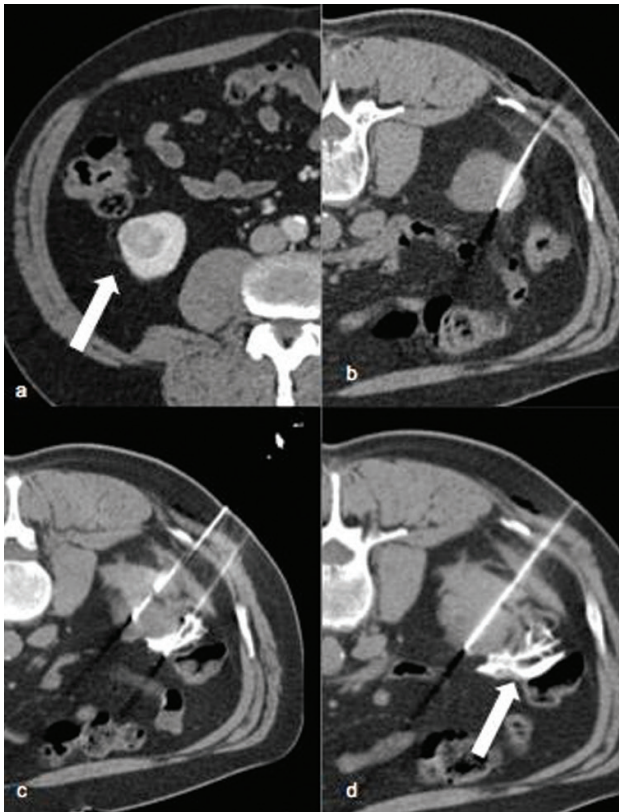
3a) Venous phase CT scan reveals a 3.2 cm exophytic lesion in the lower pole of the right kidney in a single kidney patient (arrow). 3b) An RFA probe is inserted under CT guidance in the middle of the lesion. 3c and 3d) a biopsy lesion is parallel inserted and a fine needle is inserted in the space between the lesion and the bowel loop following injection of 5% dextrose with traces of contrast (arrow)
